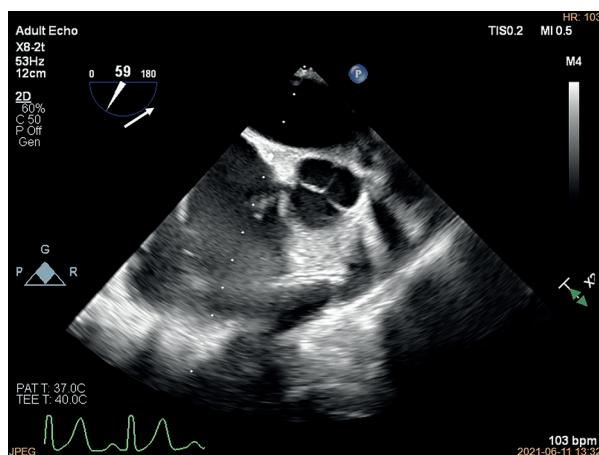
Transoesophageal echocardiographic image. There was no vegetation of the aortic valve (arrow), 3-leaflet aortic valve, leaflets not thickened
